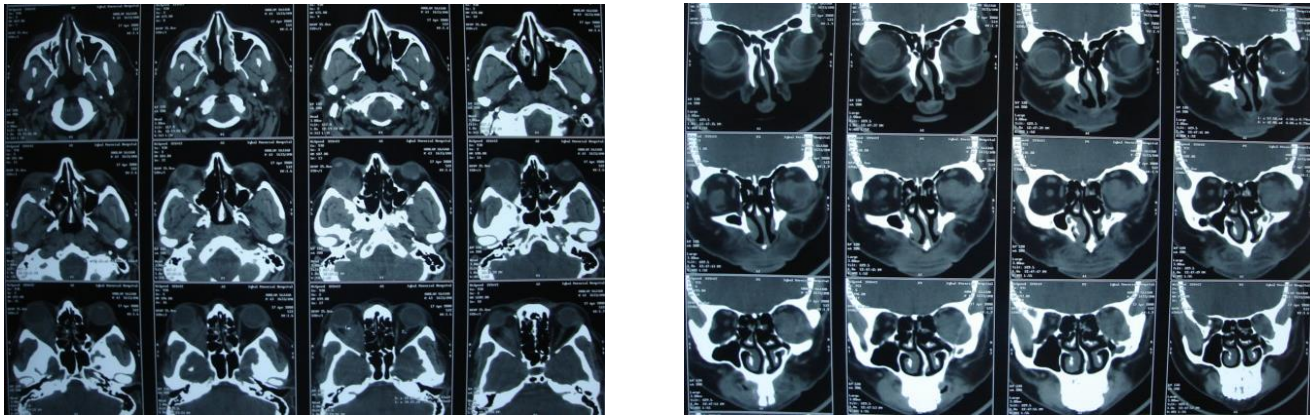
CT Scan (left) axial and (right) coronal views. Isodense, SOL was seen in retro bulbar and below the optic nerve. Normal Med rectus and slightly thickened Lateral rectus were displaced away from the mass.
